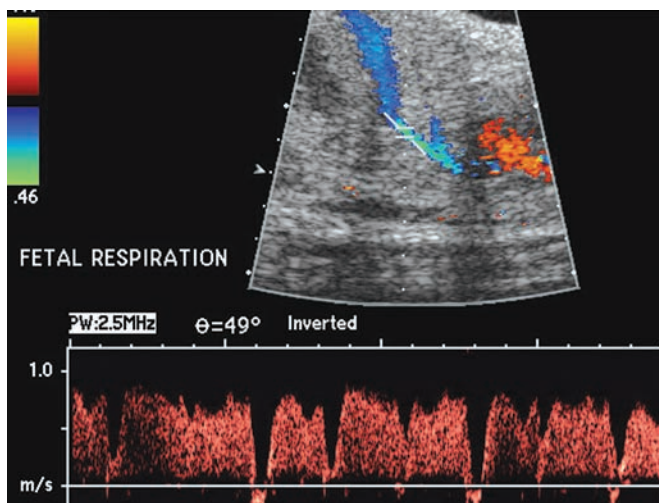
Doppler flow waveforms during breathing movements in the DV.
